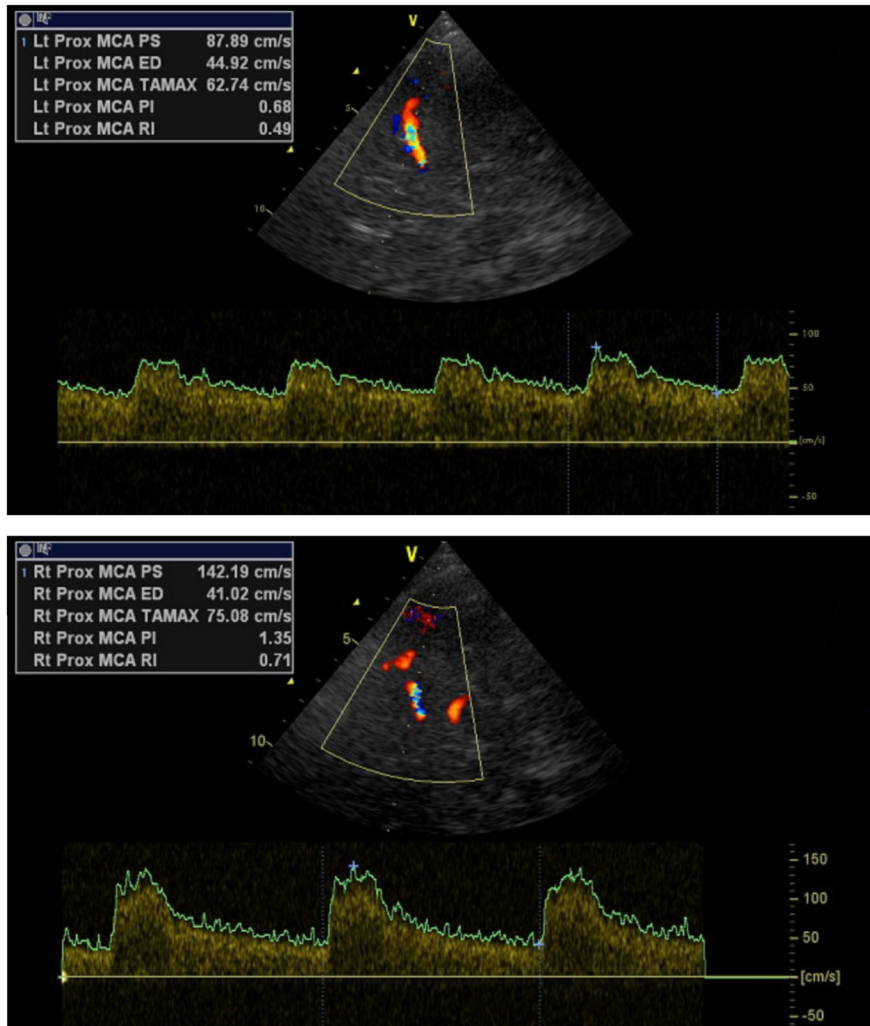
We used a transtemporal acoustic window for pulse wave transcranial color-coded Doppler, and insonated MCA at a depth of approximately 55 mm. Systolic velocity was measured in both MCAs in the whole length of MCAs first segment (M1). Peak systolic velocity, end diastolic velocity, and PI were registered. The upper image shows PI within the lower quartile, whereas the lower image shows PI within the upper quartile.
